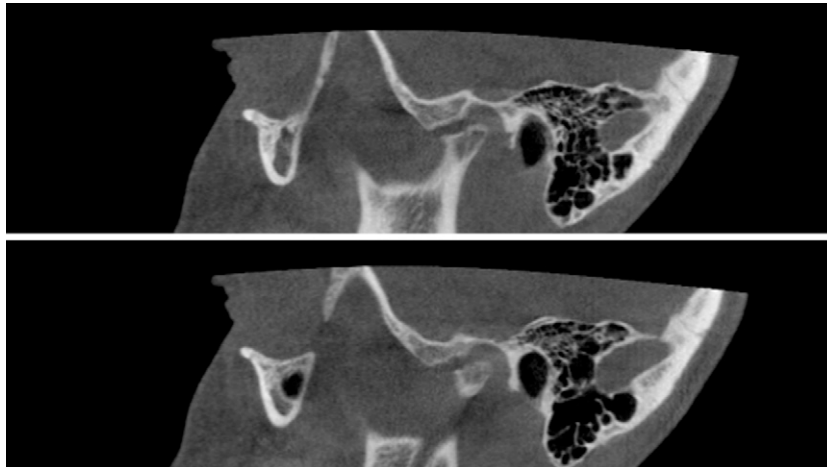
CBCT of juvenile idiopathic arthritis: deformed (remodelled) joint with surface erosions: flattened condyle with enlarged anteroposterior dimension and double contour. Articular eminence also flattened (female, 16 years).
